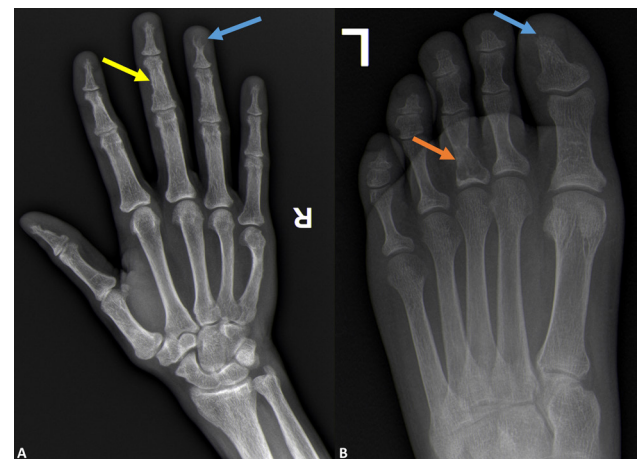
Magnified radiographs of the right-hand (A) and left-foot (B) demonstrate acro-osteolysis of the phalangeal tufts of the fingers and toes (examples pointed by blue arrows) and subperiosteal resorption along the radial aspects of the middle phalanges of the fingers (example pointed by yellow arrow), characteristic features of hyperparathyroidism. A lytic lesion in the proximal phalanx of the third toe (orange arrow), consistent with a brown tumour, is also present.
